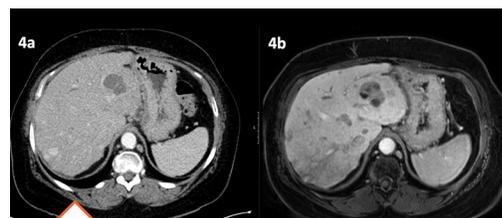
Case 1 pre-therapeutic CT imaging shows multifocal metastatic hepatic lesions in segments 4 a & b.
